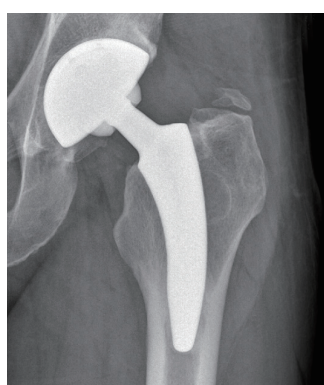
Exemplary X-ray of one of the nine cases with a heterotopic ossifications grade I according to Brooker.
